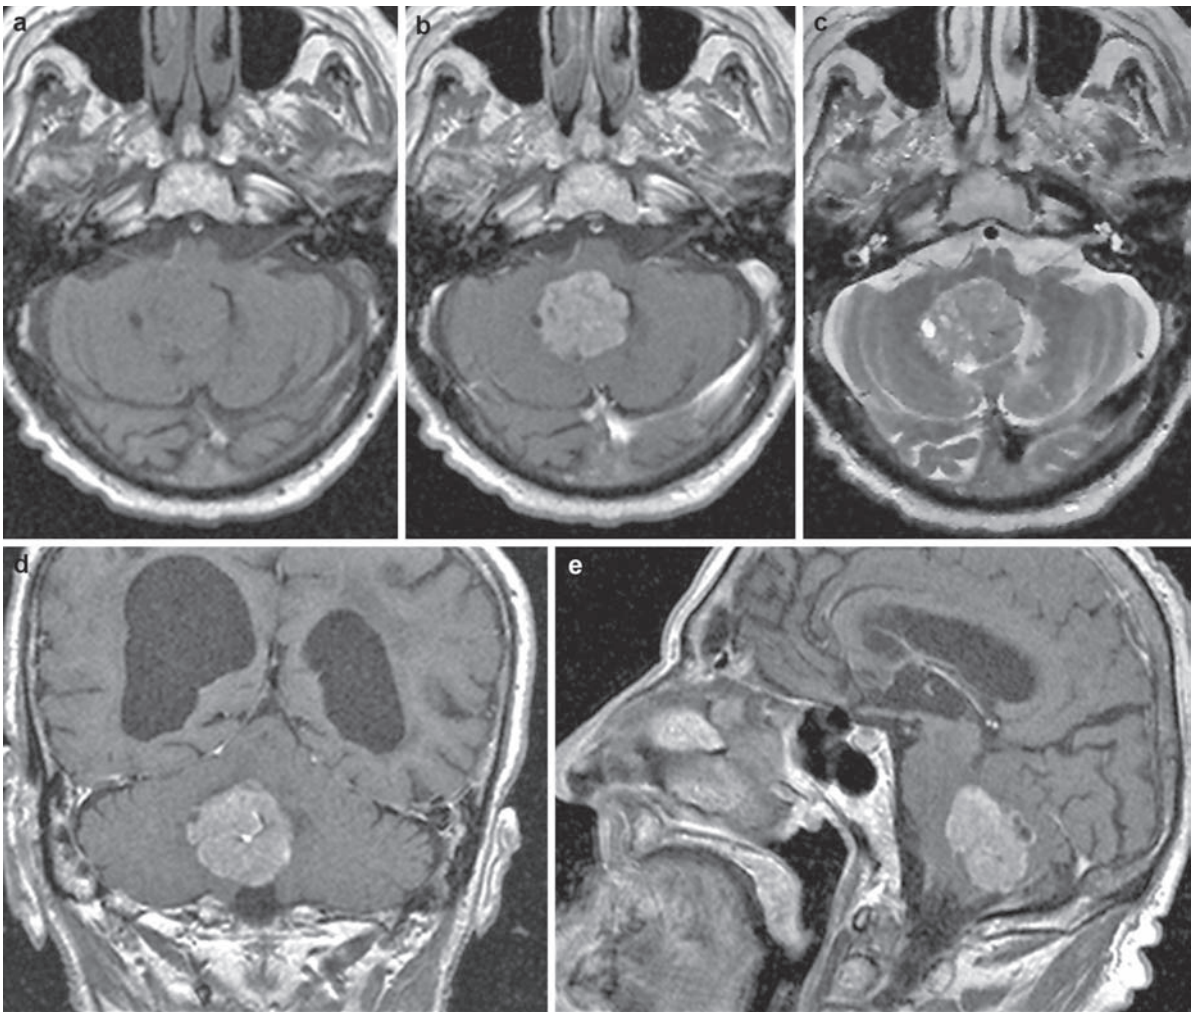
(a–e) Medulloblastoma of an 81-year-old male patient. Axial T1-weighted image demonstrates an isointense lesion in the fourth ventricle (a) with some cystic areas (c).
